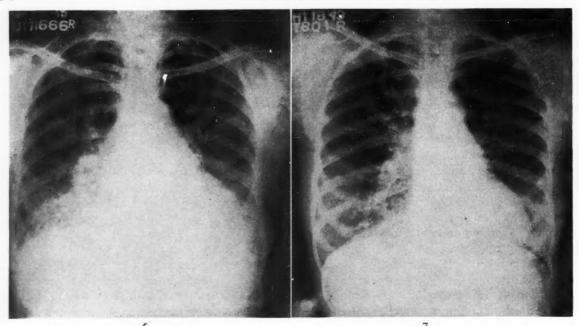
Case v. X-ray of the chest at the time of the first physiologic studies. Fig. 7. Case v. X-ray of the chest at the time of the second physiologic studies.
